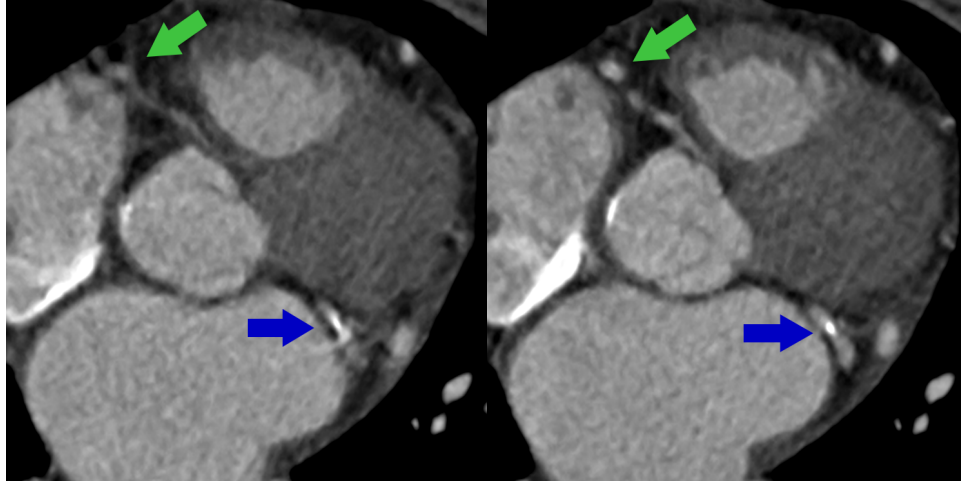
Comparison of the diagnostic quality of the RCA and LCX for the CT scanner predicted quiescent phase (a) and calculated optimal quiescent phase (b). The RCA is indicated by a green arrow and the LCX is indicated by a blue arrow.
